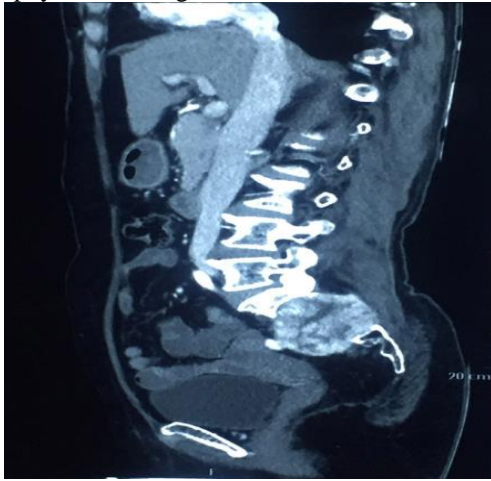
CT Scan of lytic lesion in right side sacrum
